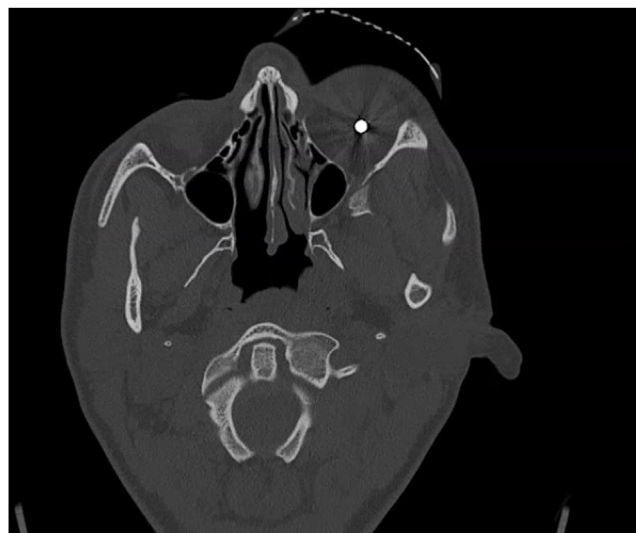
Axial CT showing BB projectile within the left globe.
